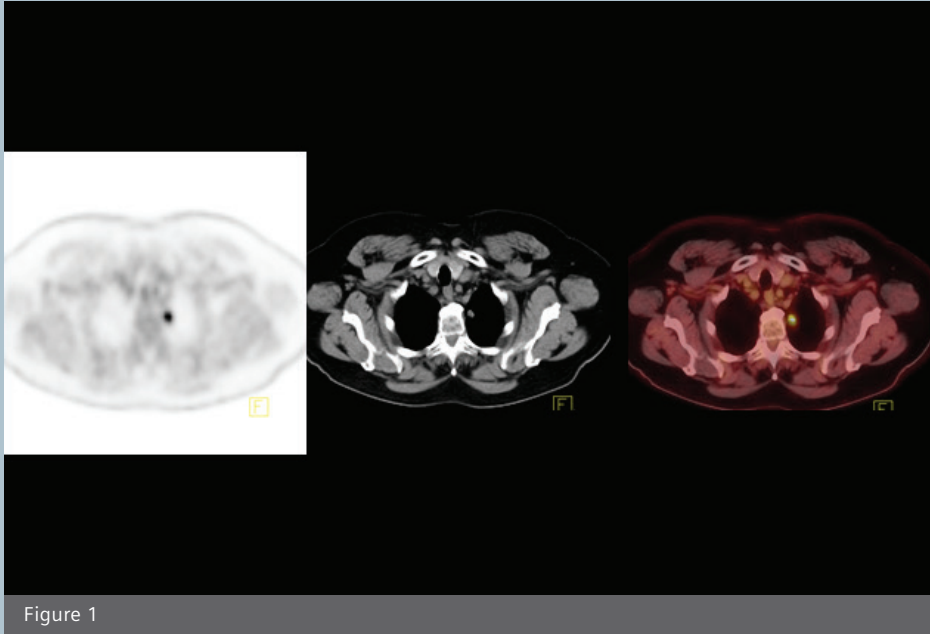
Solitary lung nodule <1 cm in diameter without characteristic CT findings like spiculated edges or calcification. High ^{18}F FDG uptake (SUV_{max} 5.4) strongly suggests malignant nodule.
